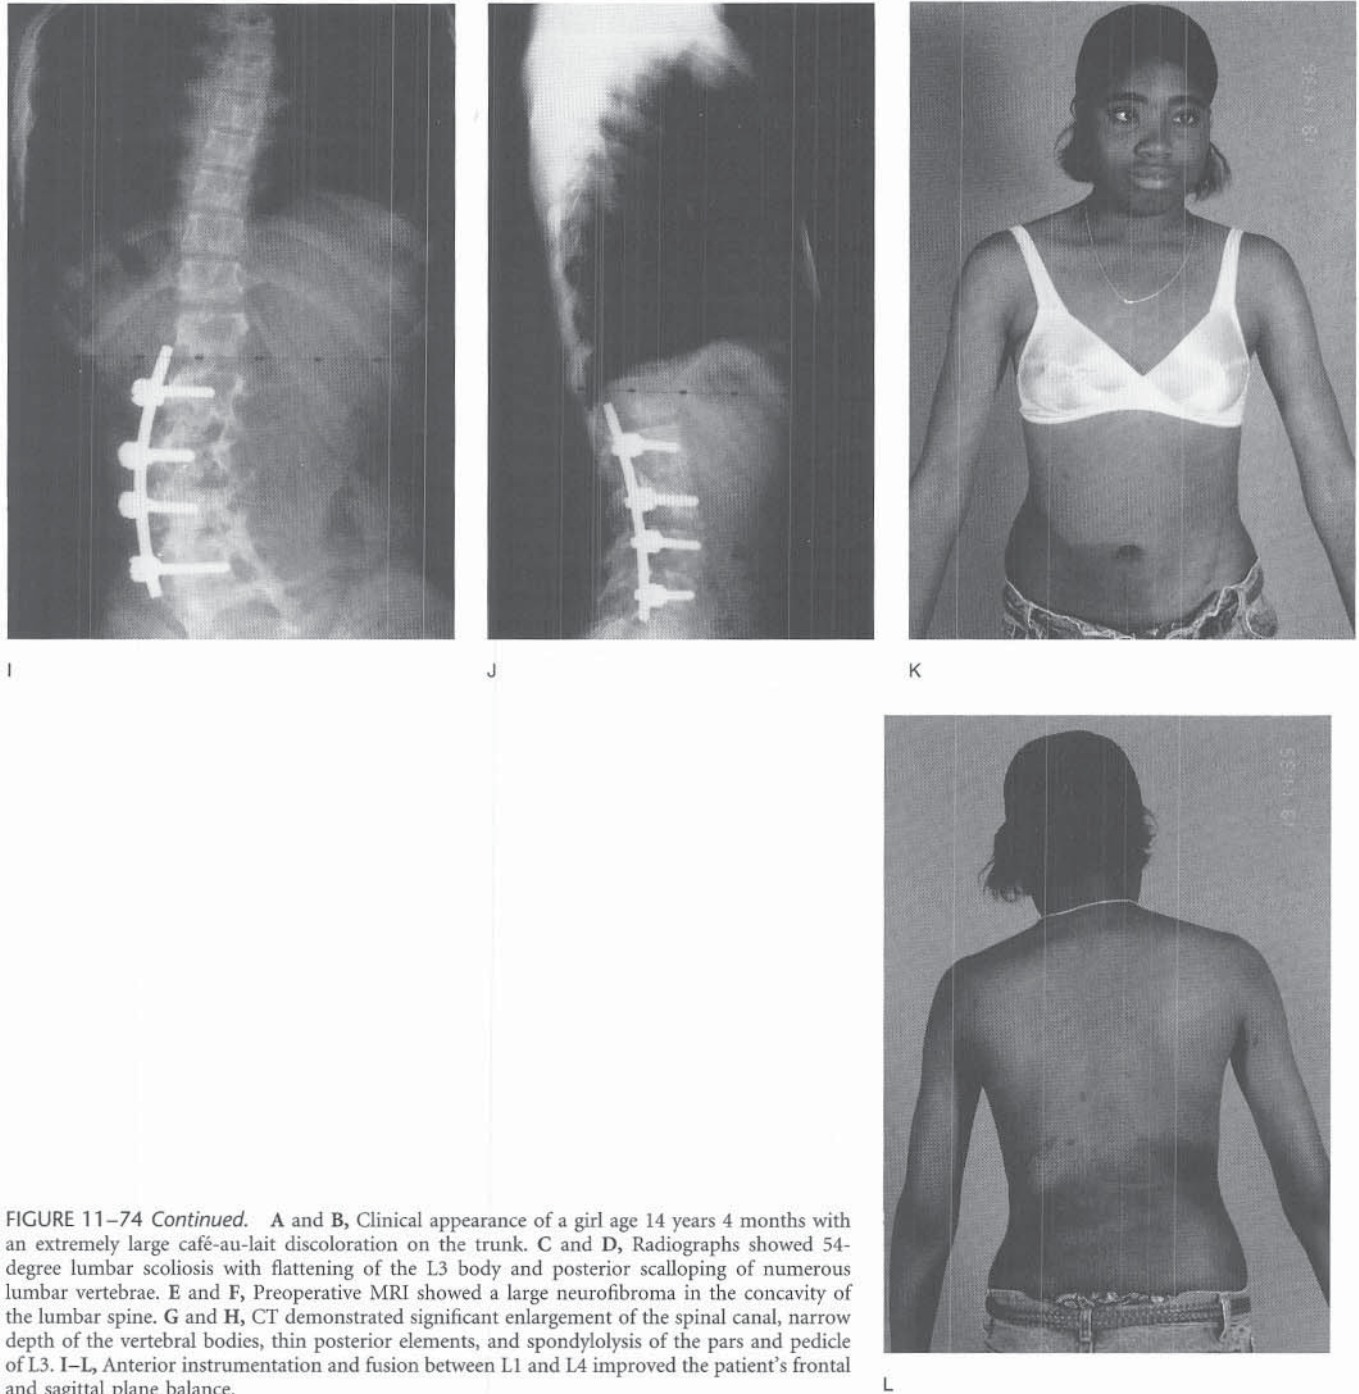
Continued.* A and B, Clinical appearance of a girl age 14 years 4 months with an extremely large café-au-lait discoloration on the trunk. C and D, Radiographs showed 54-degree lumbar scoliosis with flattening of the L3 body and posterior scalloping of numerous lumbar vertebrae. E and F, Preoperative MRI showed a large neurofibroma in the concavity of the lumbar spine. G and H, CT demonstrated significant enlargement of the spinal canal, narrow depth of the vertebral bodies, thin posterior elements, and spondylolysis of the pars and pedicle of L3. I-L, Anterior instrumentation and fusion between L1 and L4 improved the patient's frontal and sagittal plane balance.
